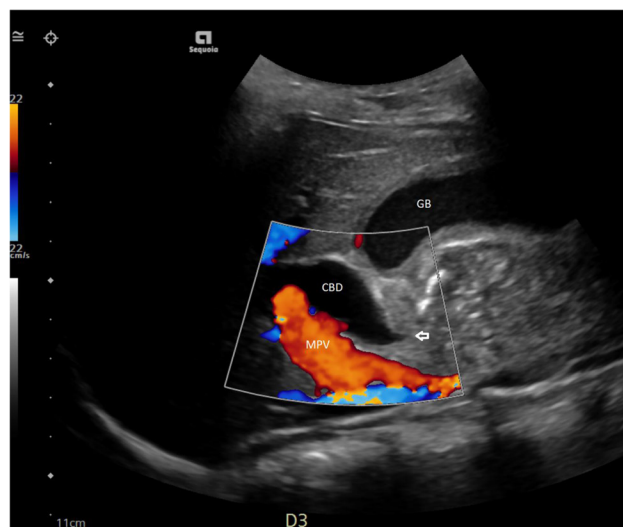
Ultrasound image demonstrates dilated common bile duct (CBD) with distal tapering indicated by the open white arrow anterior to the main portal vein (MPV). Gallbladder (GB) is shown with mild edema and sludge.
